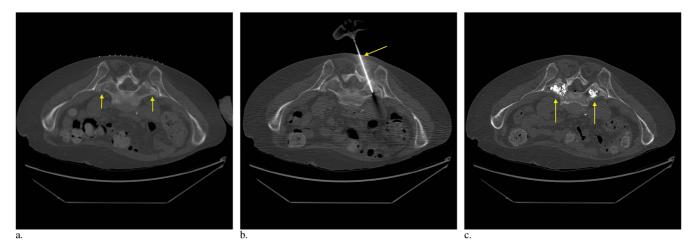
Noncontrast pelvic CT demonstrates (a) bilateral pelvic insufficiency fractures (arrows), (b) placement of a 13-gauge needle (arrow) within the left sacral fracture, and (c) postoperative appearance of polymethylmethacrylate cement within the sacral alae (arrows). (Available in color online at *www.jvir.org.*)
